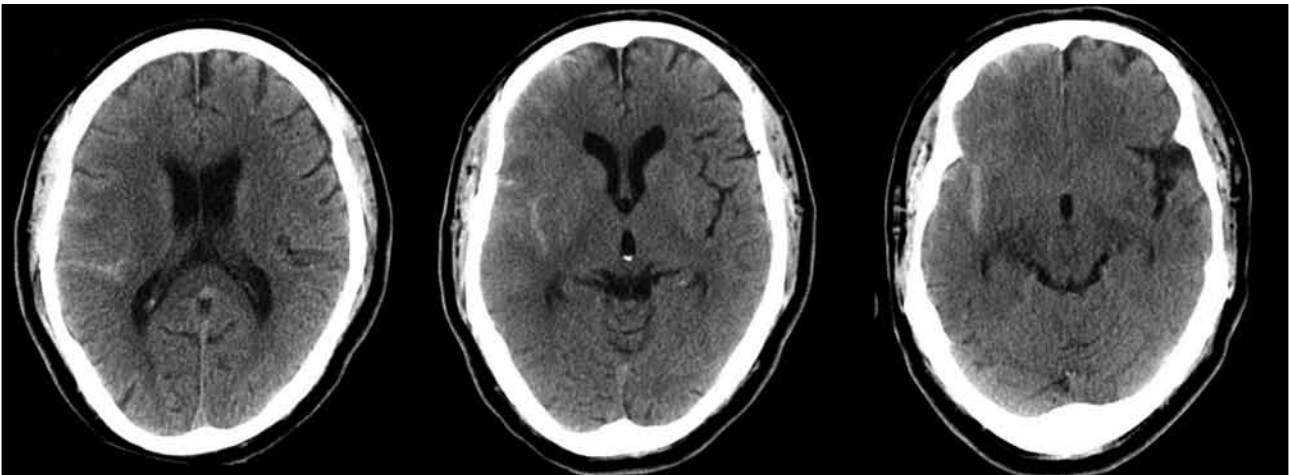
Axial slices from computed tomography brain at re-admission on day 16 after carotid artery stenting showing right-sided acute subarachnoid haemorrhage.
